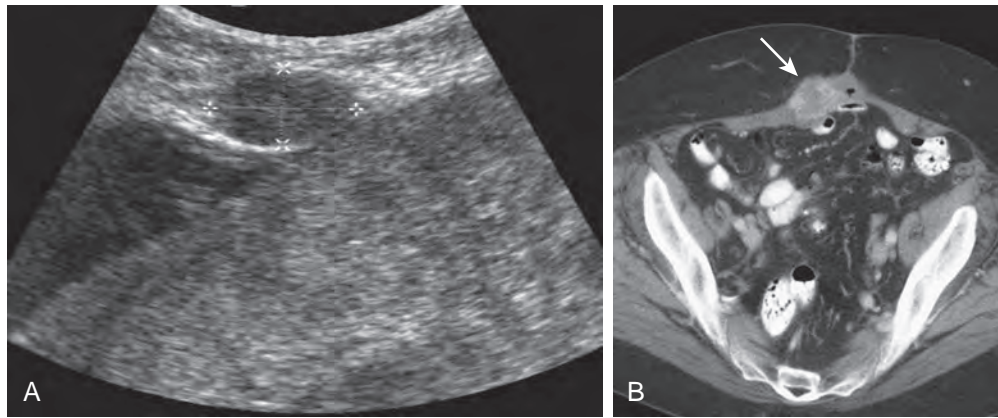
Abdominal wall metastatic malignant neoplasm. A. Longitudinal sonogram demonstrates a hypoechoic metastasis (cursors) within the subcutaneous fat of the anterior abdominal wall from a gastric carcinoma. B. Enhancing abdominal wall metastasis (arrow) from colon cancer.
